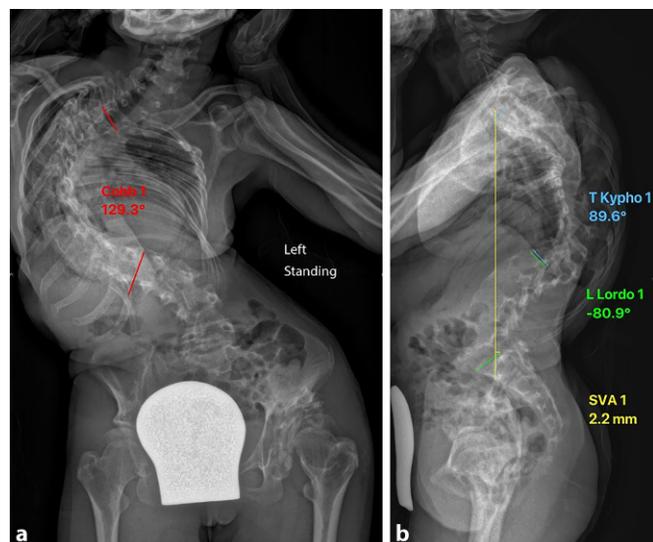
◀ Radiographs in an anteroposterior (a) and lateral (b) view of the patient in a standing position. *T Kypho* thoracic kyphosis, *L Lordo* lumbar lordosis, *SVA* sagittal vertical axis
